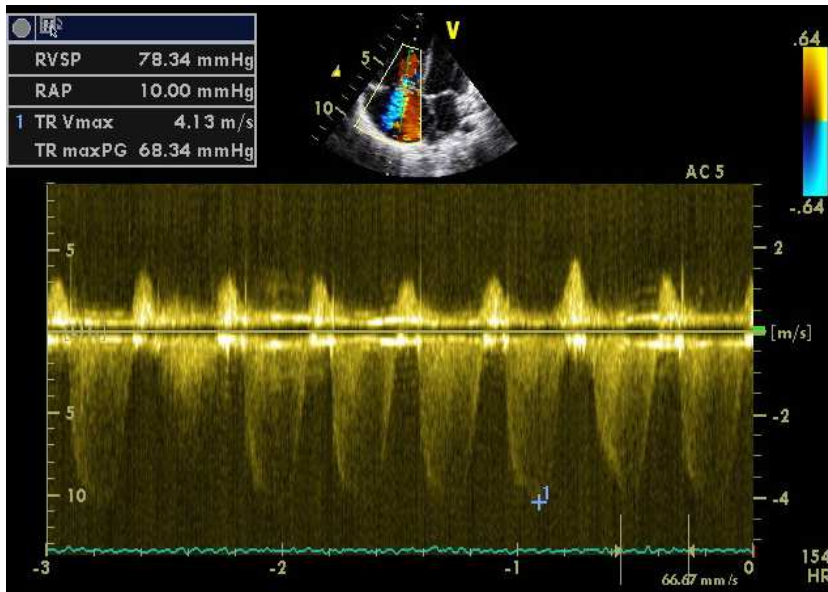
Sample Echocardiogram of severe pulmonary hypertension.
